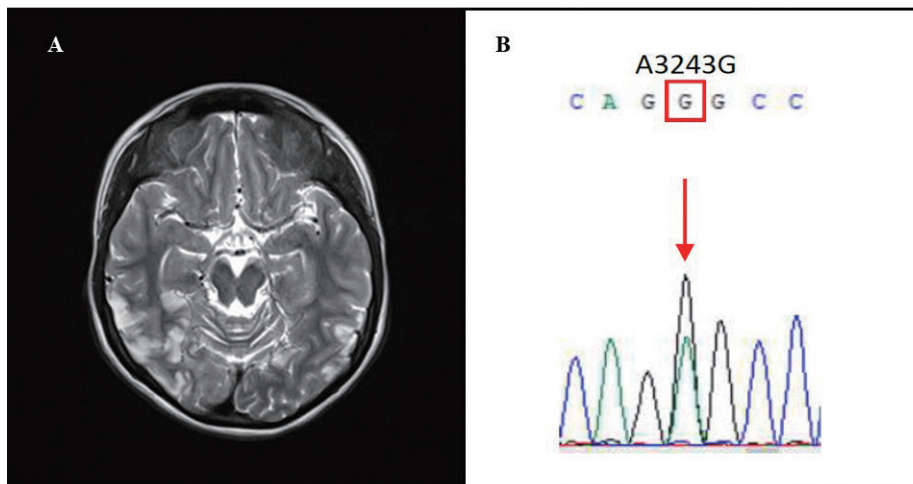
MRI of brain showed of multiple ill-defined long T2 areas in cortical / subcortical regions of bilateral temporo-parieto-occipital lobes, more on the right side (A). Mitochondrial gene showed mutation in mtA3243G with 64% heteroplasmy. (B)
